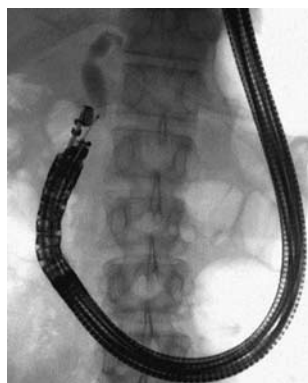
Endoscopic ultrasound-guided biliary drainage^[9].
